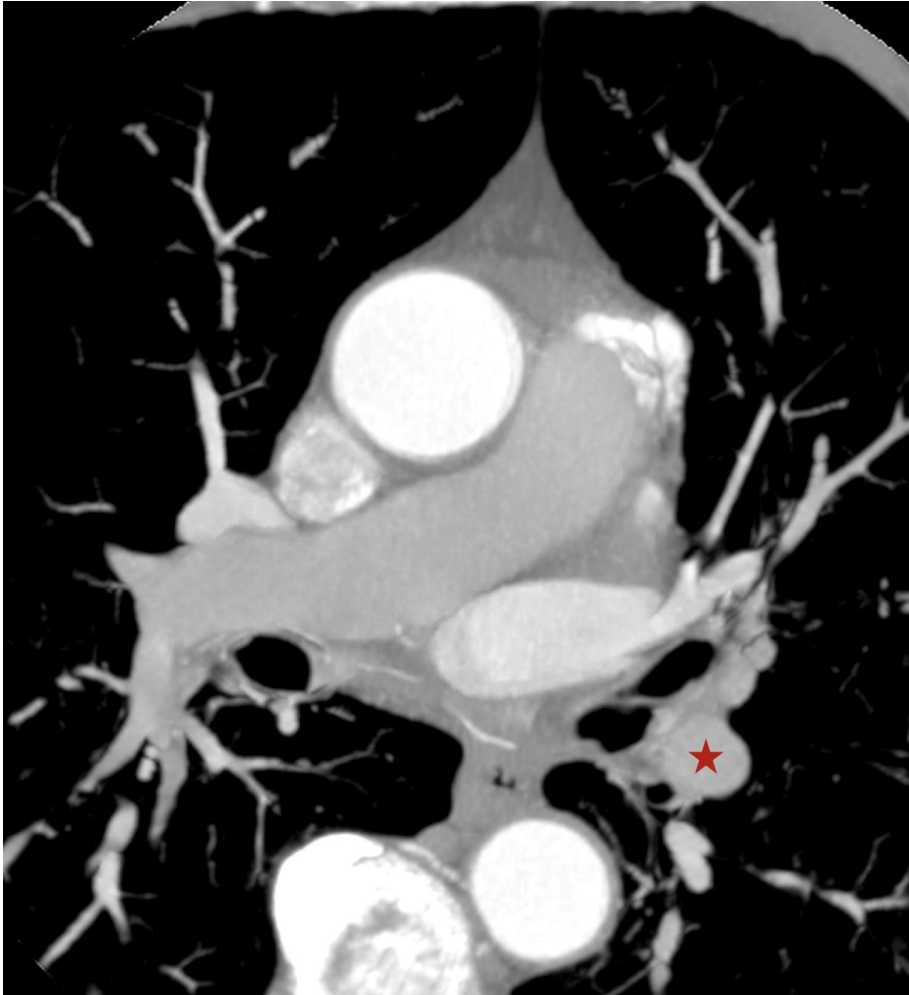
Coronary CT Scan, axial view just under the pulmonary artery branching showing the arterial confluence (red star) created by the CBF near the left atrial appendage. MIP 6 millimeters.
